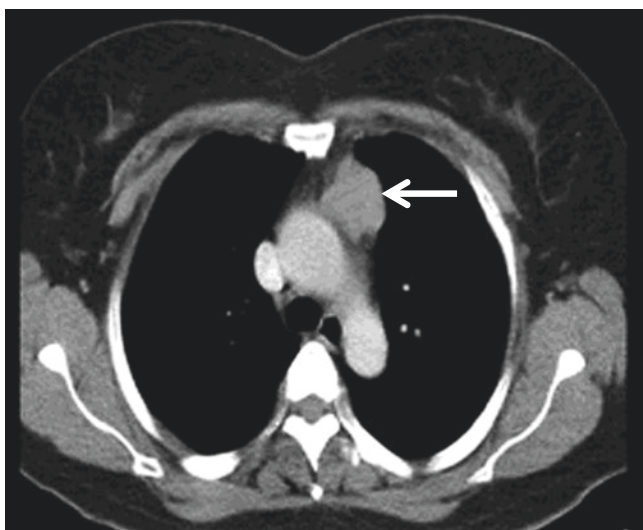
Chest CT shows occupying lesions in the anterior mediastinal
